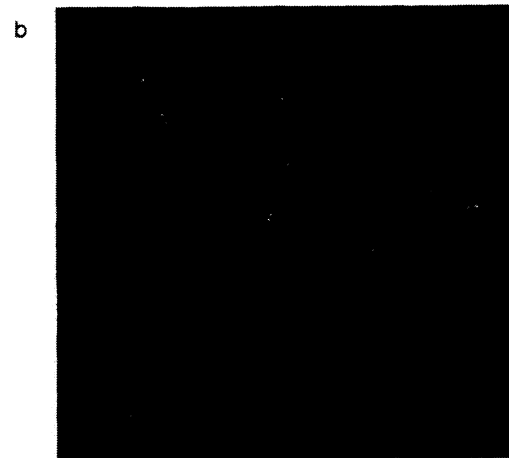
A radiograph of a malignant cluster of calcifications (a). Also shown are 2 reconstructions of the cluster (b,c). The reconstructions show a branching linear structure demonstrating ductal confinement of calcifications typical of a ductal carcinoma.
